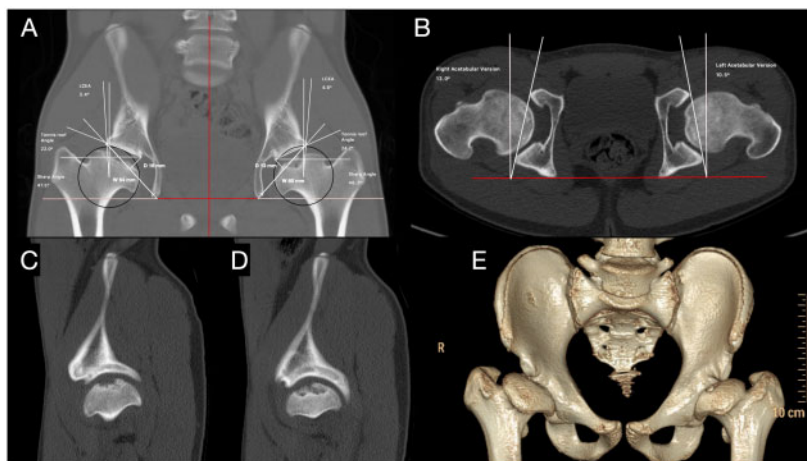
Preoperative CT scan of the pelvis. Coronal (A), axial (B), right (C) and left (D) sagittal sections and three-dimensional reconstruction (E). Dysmorphic femoral heads not well covered by the acetabulum, trochanteric overgrowth, normal acetabular anteversion and central osteochondral lesion. Measurements for right/left hip were: Lateral Center-Edge Angle (LCEA): $3.4^{\circ}/4.6^{\circ}$; Tonnis roof angle: $22^{\circ}/24.2^{\circ}$; Sharp angle: $47.5^{\circ}/48.3^{\circ}$; Acetabular depth-width ratio calculated as depth (D)/width (W) $\times 1000$: $250/216.7$; Acetabular version: $13^{\circ}/10.5^{\circ}$.
